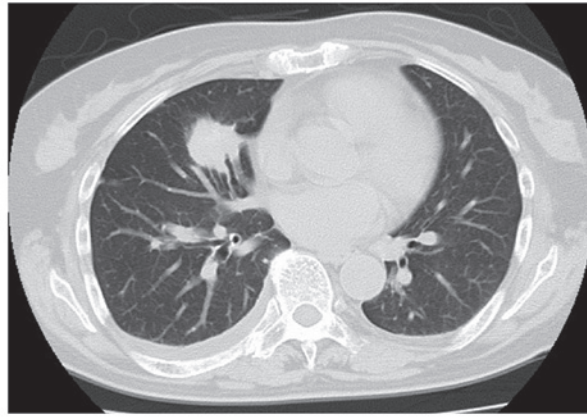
Chest computed tomography scan at the time of first presentation revealed a mass in the middle lobe of the lung.
